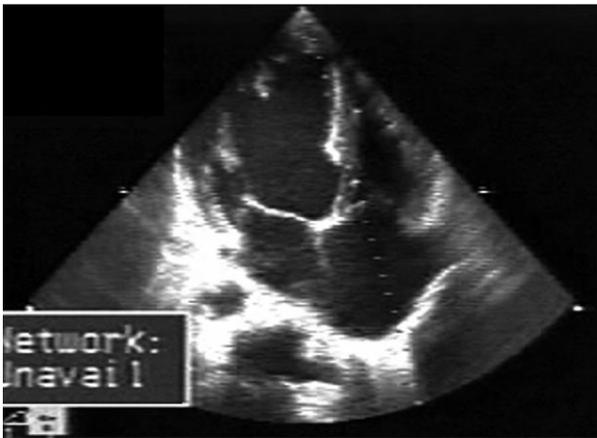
Apical four chamber view showing the enlargement of all the heart cavities and the trabecular structure of the ventricular walls.
